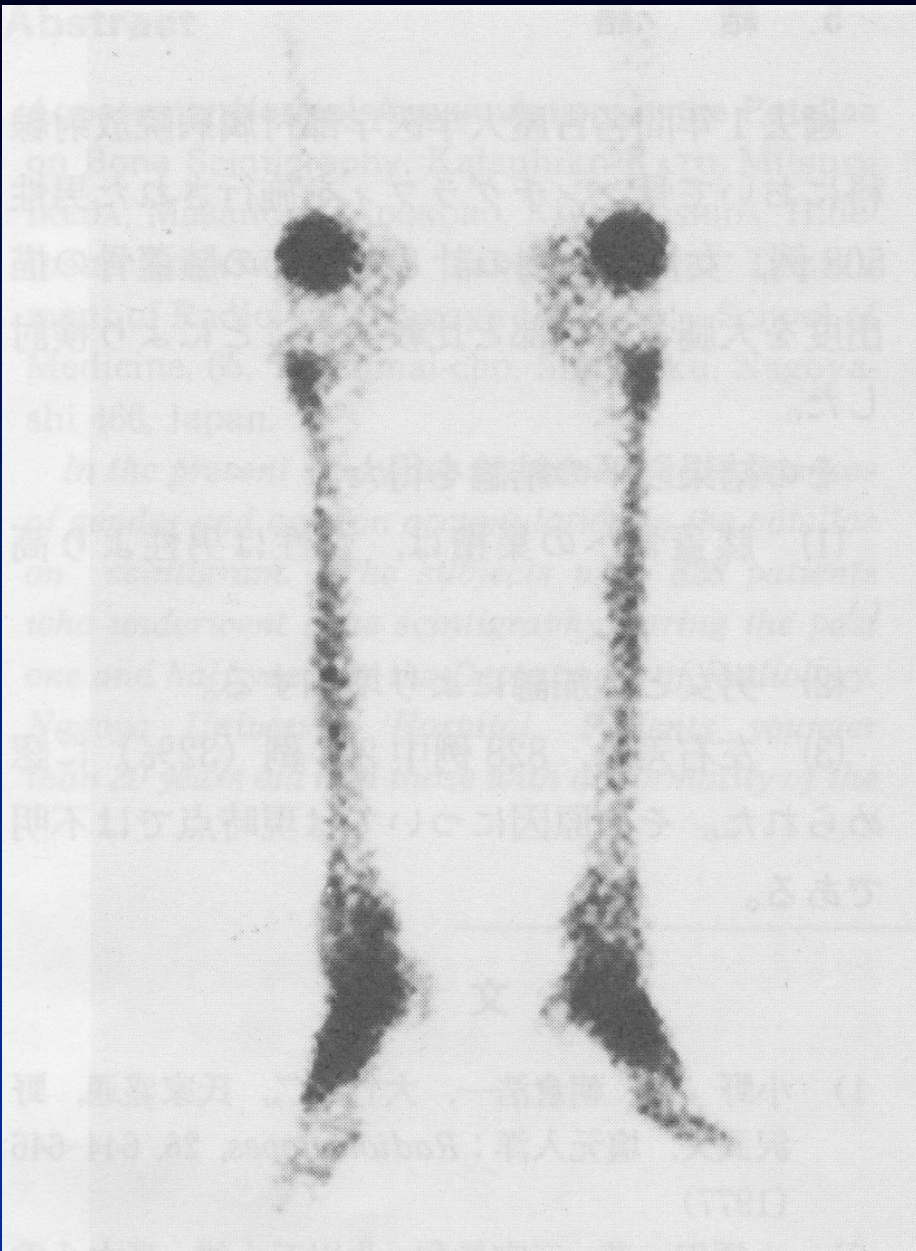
"Positive" and "Negative" scintigraphy.
